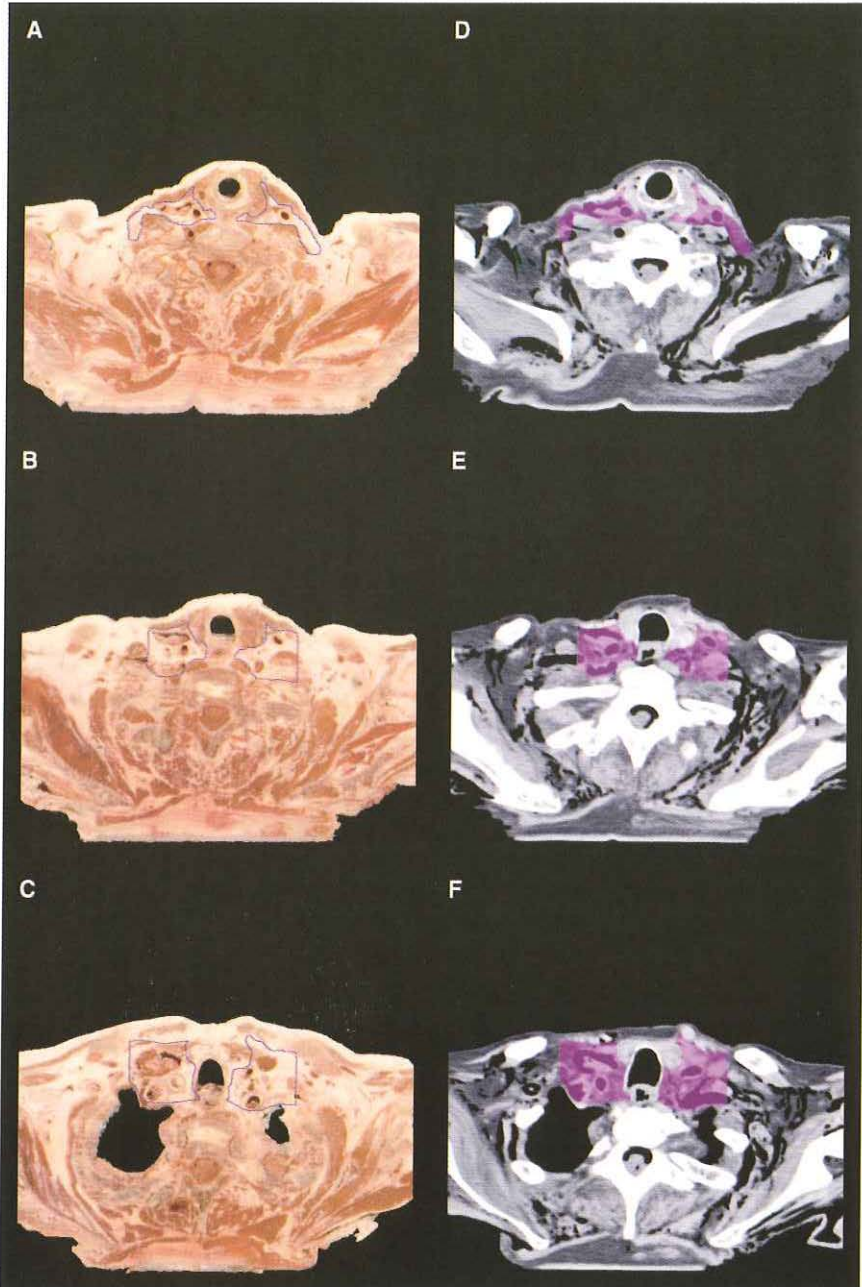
Region 4: borders are in blue outline on the anatomy slices (left) and in purple color-wash on the CT slices (right).
